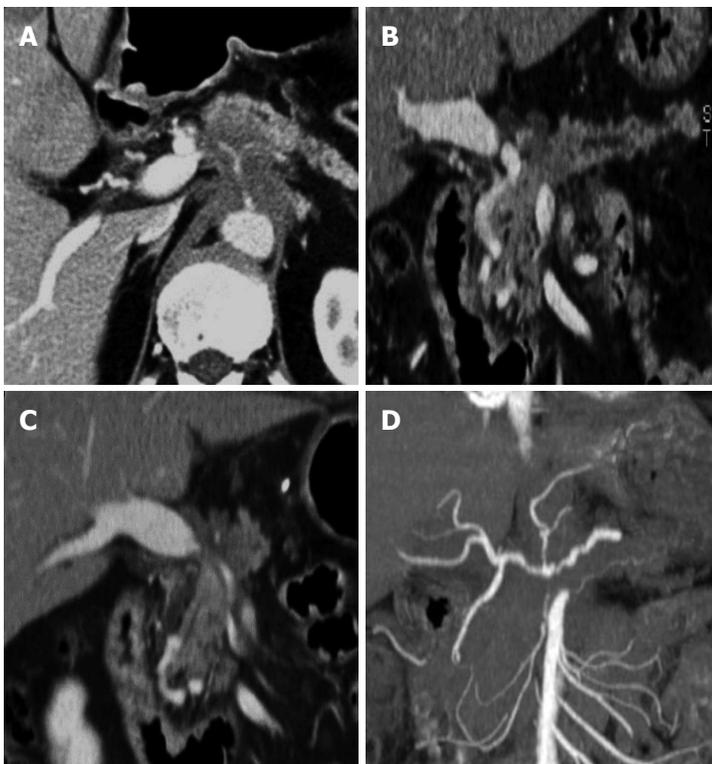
Post-process of multi-detector computed tomography for pancreatic cancer. A: In the axial CT scan, an ill-defined pancreatic body cancer invading the celiac axis is identified; B: On the curved MPR along the pancreatic duct, the relationship between the pancreatic duct and the cancer can be more easily understood; C, D: The extent and degree of major vascular involvement caused by the pancreatic cancer can be comprehensively assessed using MPR and the maximum intensity projections. MDCT: Multi-detector computed tomography; MPR: Multiplanar reformations.
